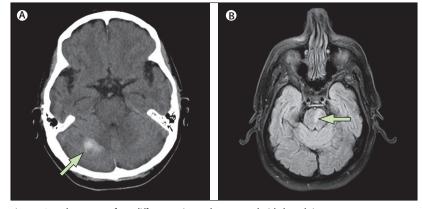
CT and MRI scans of two different patients who presented with dysarthria (A) This 67-year-old patient presented with isolated dysarthria; she had ataxic speech. There was no headache and on examination, the patient had normal finger-to-nose and gait testing. The CT scan shows a right-sided cerebellar haemorrhage (arrow). (B) This 82-year-old patient awoke with slurred speech. Although there were no motor complaints, on examination, he had a very slight right-sided pronator drift, emphasising the importance of a complete neurological examination in patients who present with neurological symptoms. The fluid-attenuated inversion recovery MRI shows a left-sided paramedian pontine infarct (arrow).
